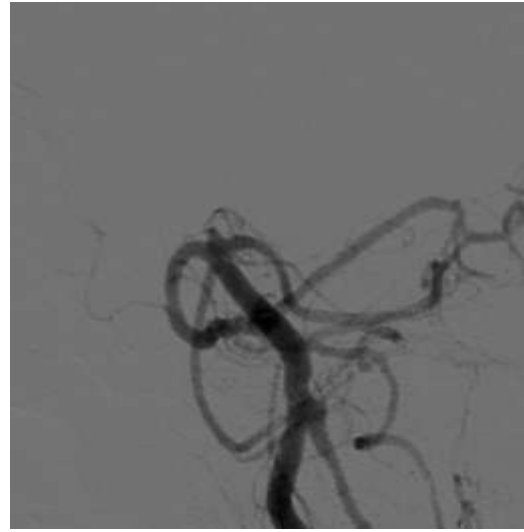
(A) CTA axial image showing a right ICA aneurysm, (B) DSA image showing right PCom aneurysm which was missed on CTA, (C) DSA image showing right ICA aneurysm which was detected by CTA (shown in image A).
